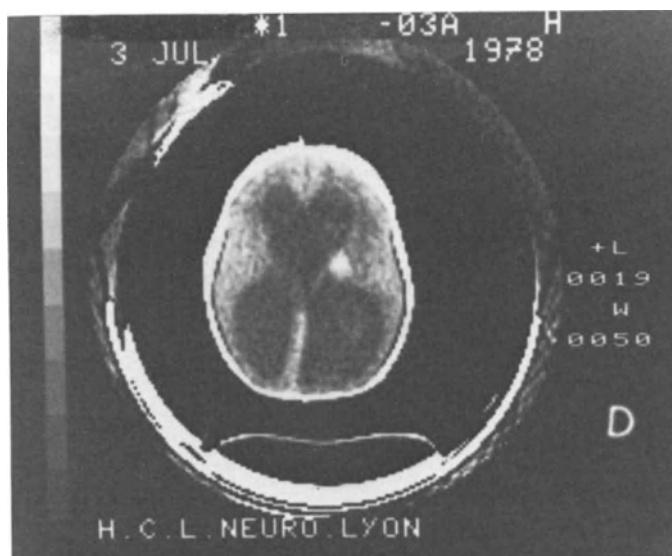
Grade I ependymoma causing congenital hydrocephalus. Unenhanced CT showing a hyperdense tumor arising from the outer wall of the ventricle. Huge symmetric hydrocephalus is present
